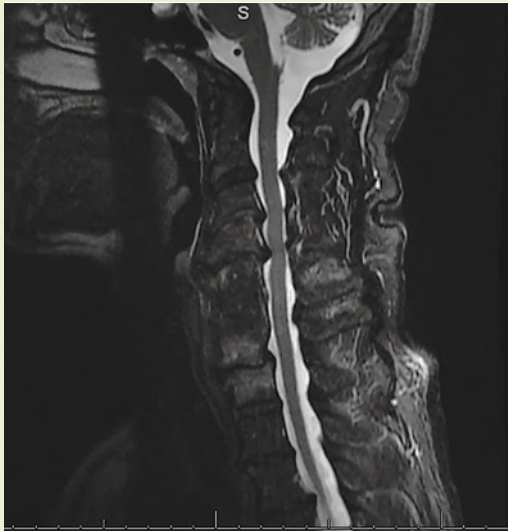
(above): Preoperative sagittal T2-weighted MRI of a cervical spine demonstrates multilevel cervical spondylosis and severe spinal cord compression.
